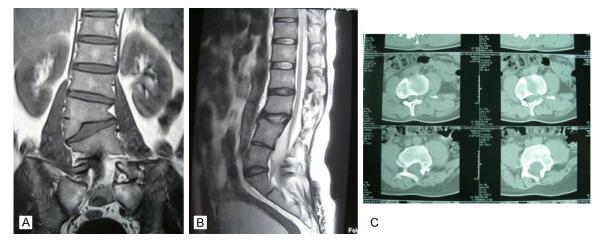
Congenital scoliosis, tethered cord syndrome in a typical case (male, 32 years old). A: Preoperative coronal MRI shows that, the right part of L3 vertebral body with L4 semi vertebral fusion, right part of the L5 vertebral body dysplasia, and sacral structure confusion. B: Preoperative sagittal MRI shows that, the position of conus medullaris is low (L4 level), with thickened filum terminale. C: Preoperative CT shows that L4 vertebral dysplasia.
